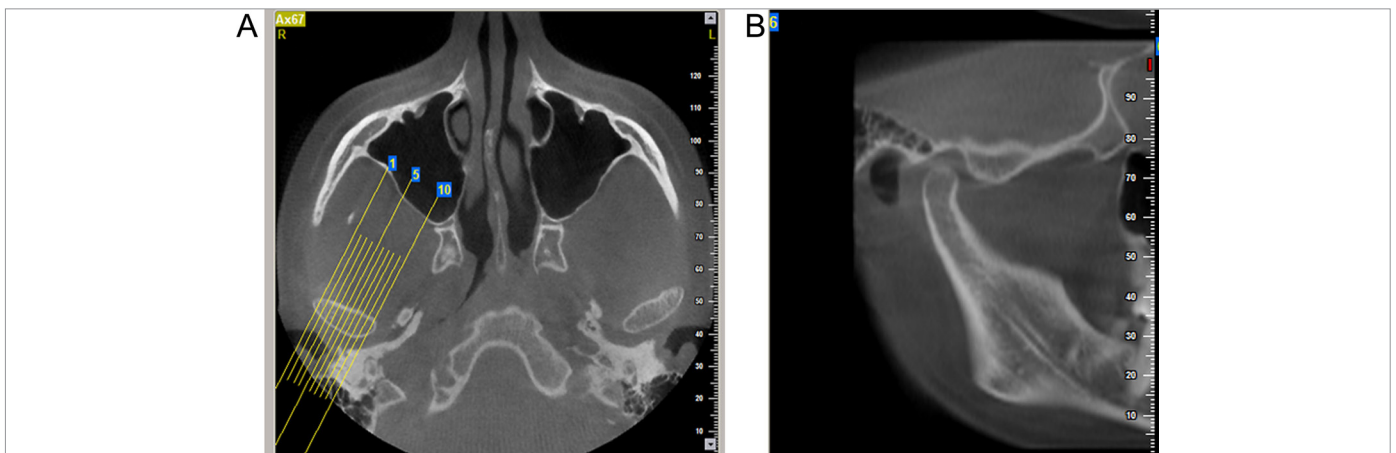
A, B. Reconstruction of CBCT sections in a sample case. (a) Axial views in which the condylar process had its widest mediolateral diameter, (b) Central sagittal section of the condyle
